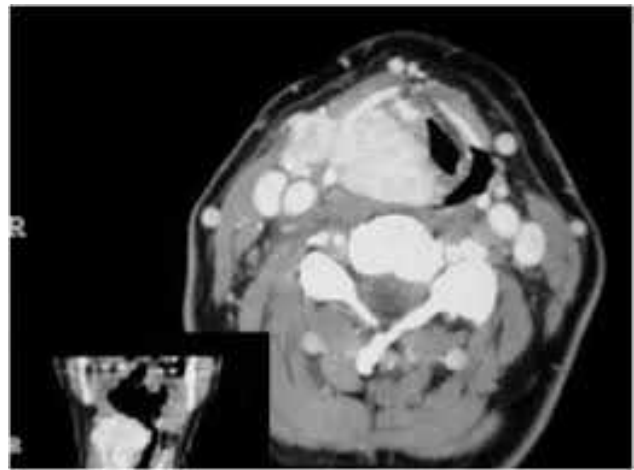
Axial computed tomography scan showing a right-sided, smooth supraglottic mass obscuring laryngeal inlet
